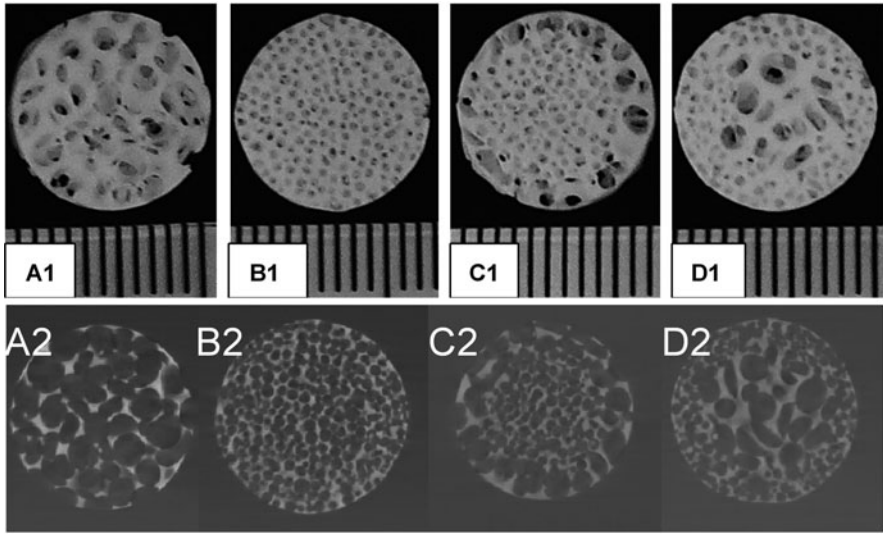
Representative 3D digital images (A1, B1, C1 and D1) and 2D Micro CT images (A2, B2, C2 and D2) of the biodegradable β -TCP scaffolds by a template-casting method. (a) is the scaffolds with uniform big pores; (b) is the scaffolds with uniform small pores; (c) is the FGS with central small pores and peripheral big pores; (d) is the FGS with central big pores and peripheral small pores
